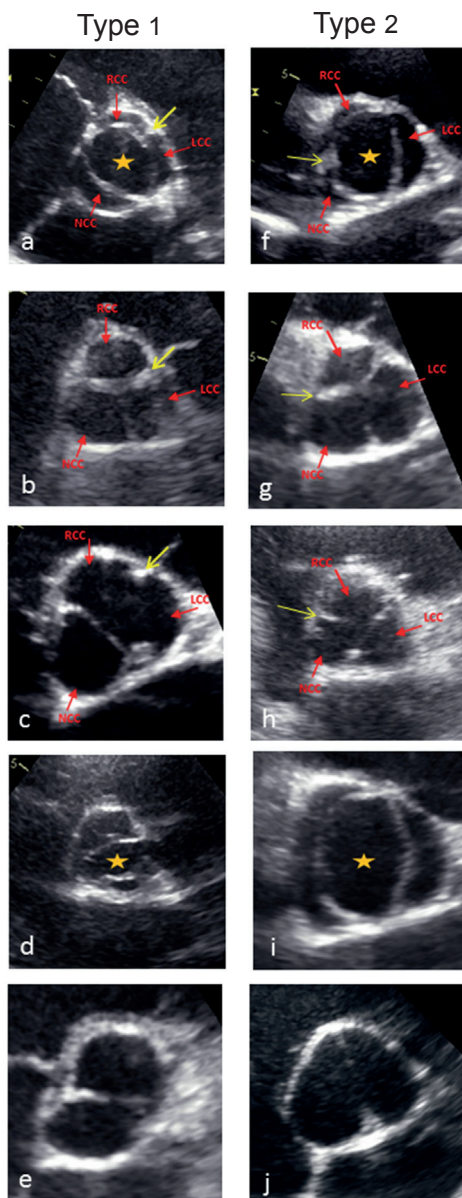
Representative examples of different BAV types as seen from the short-axis parasternal view on echocardiography.
